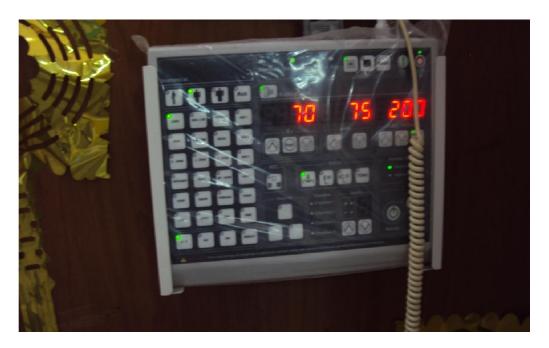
X-ray board control. k.v= 70, time=75, current=200 mAmper
